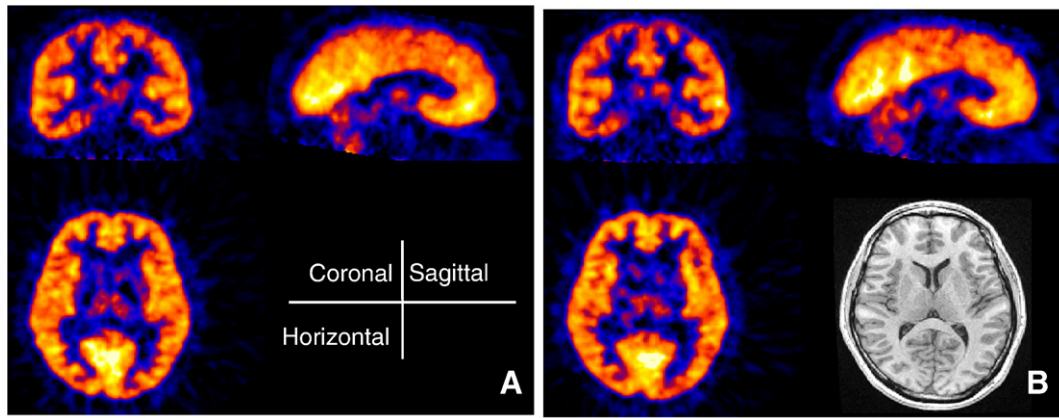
Summation images of [^{11}C]flumazenil (A) and [^{18}F]flumazenil (B) of Subject A from 0 to 93 min after i.v. injection. Coronal, sagittal, horizontal and T_1 -weighted MR images are shown. Note no uptake of both radioligands in the skull, which is evident by visual inspection of PET and MR images.
